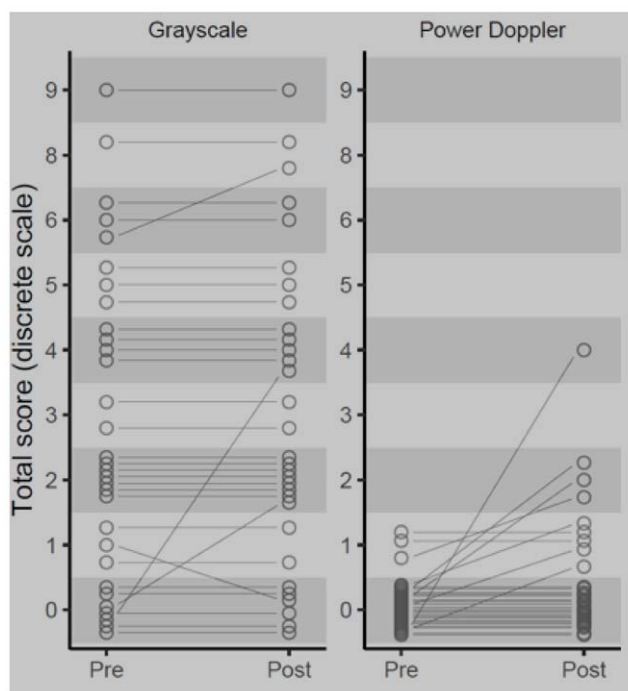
Ultrasound scores before and after training. Figure 1. A Spaghetti plots depicting individual Gray-Scale and Power Doppler ultrasound scores before and after training
